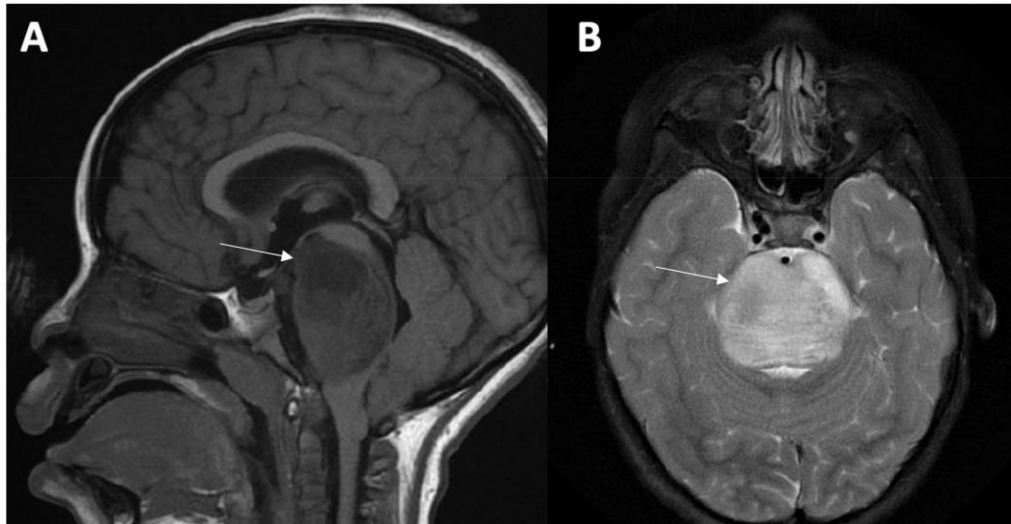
DIPG tumor imaging at the pons. MRI of the brain of a child with H3K27M-altered glioma. The imaging demonstrated a (A) sagittal T1 hypointense and (B) axial T2 hyperintense DIPG tumor occupying nearly half of the axial diameter. Arrows indicate the tumor. Reproduced from reference²⁰.
